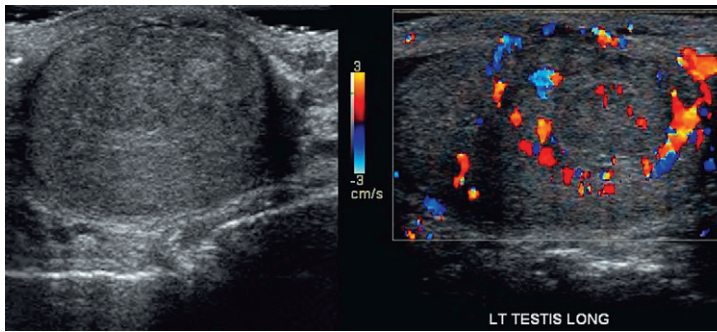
Grey-scale and colour Doppler longitudinal images of the left testis being evaluated for a palpable mass. The normal testicular echotexture is distorted. There is a slightly hypoechoic mass. Colour Doppler shows a rim of hyperaemia, but the central portion of the mass is relatively avascular.
